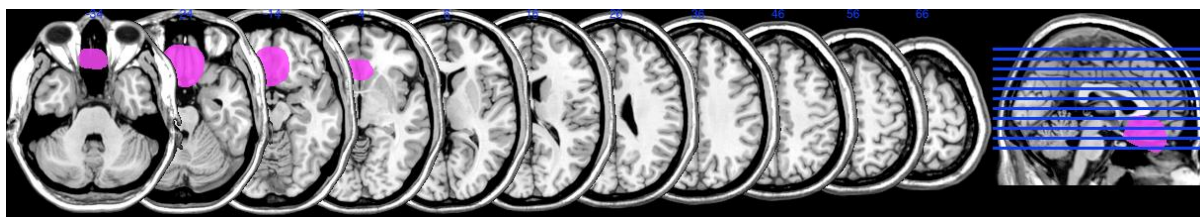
MRI scan of patient WR
